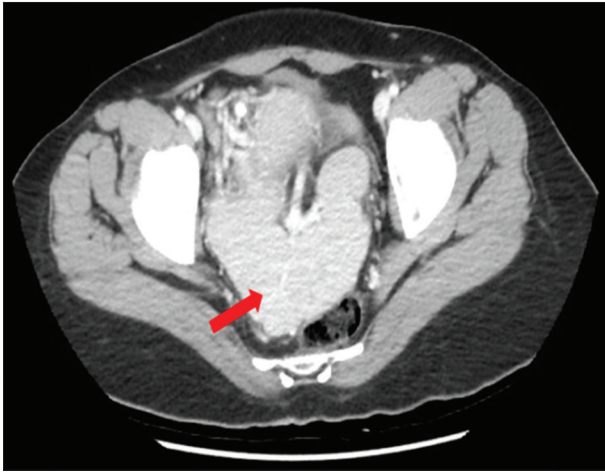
Axial view of the computed tomography scan showing the spleen in the pelvic cavity
